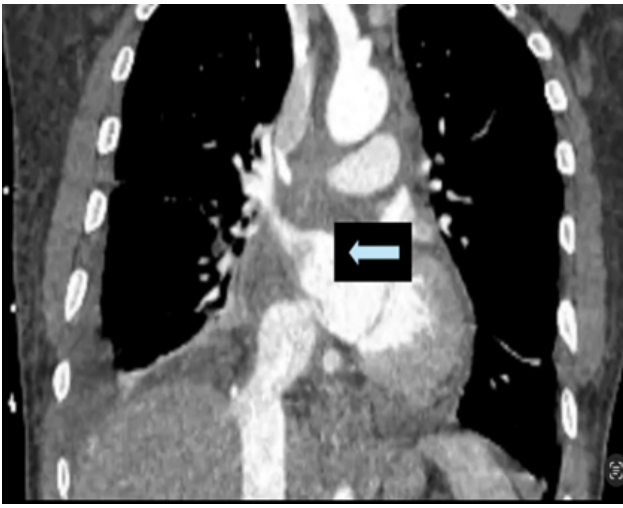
Coronal CT demonstrating right atrial mass measuring 5.6 x 5.3 x 4.9 cm, invading the superior vena cava with thrombosis and right atrial wall.
